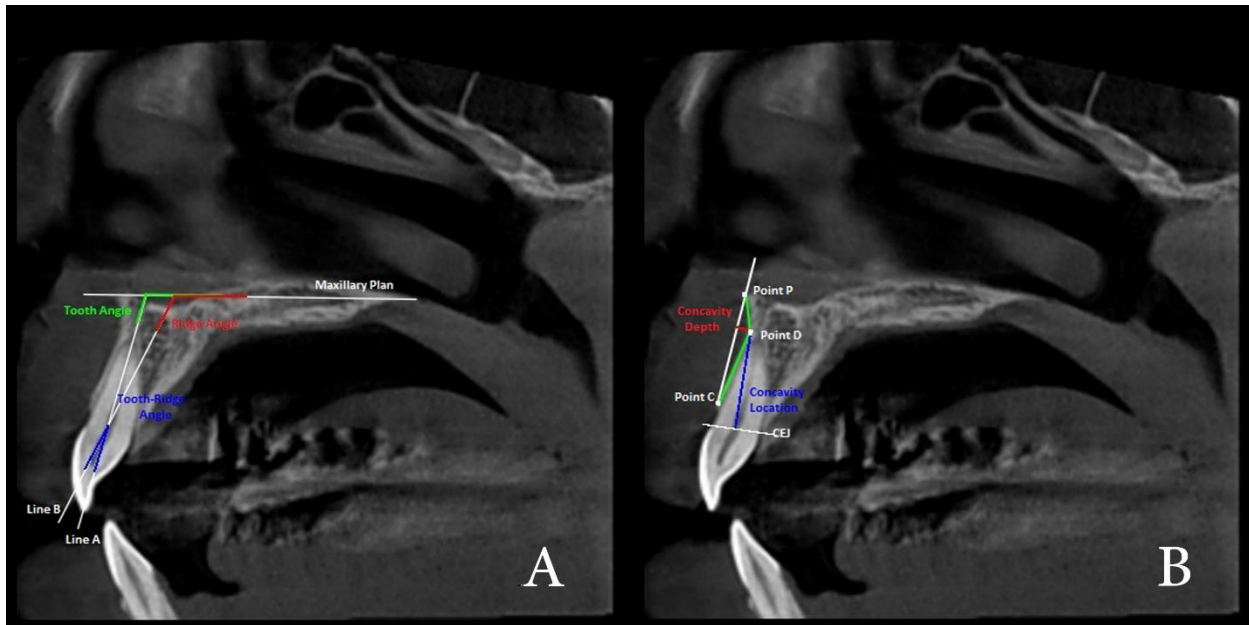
Radiographic picture for measurements of morphologic features of maxillary anterior esthetic zone before implant placement. Tooth angulation (TA) and tooth-ridge angle (TRA) (fig.3A) ,c oncavity depth (CD) ,concavity angulation (CA) ,concavity location (CL) (fig. 3B) .
